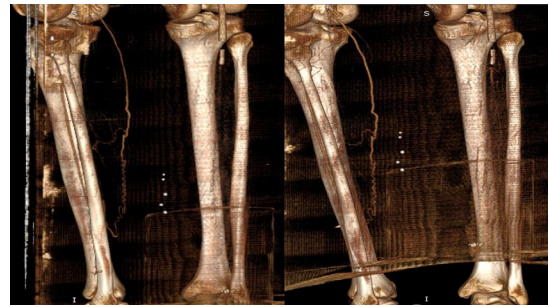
CT Scan – left picture it's an anterior oblique view of BTK before ablation, where we can appreciate some collateral system on the left BTK and none of right BTK; right picture its compared 1 month after ablation, where we appreciate a huge and large developed collateral system on both BTK
